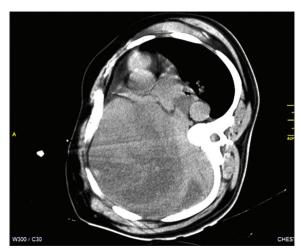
Contrast-enhanced computed tomography scan of thorax showing huge right sided pleural based heterogeneous intraparenchymal mass occupying almost whole of the right hemithorax with contralateral shifting of the mediastinum
